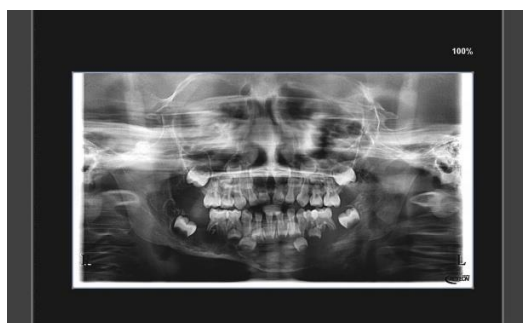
Panoramic radiograph of a 3-year-old girl showing a poorly defined radiolucent lesion in the anterior region of the mandible, involving the developing primary and permanent teeth.
